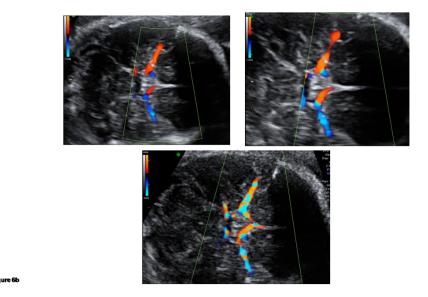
Technique of measuring the middle cerebral artery Doppler 338x190mm~(96~x~96~DPI)
